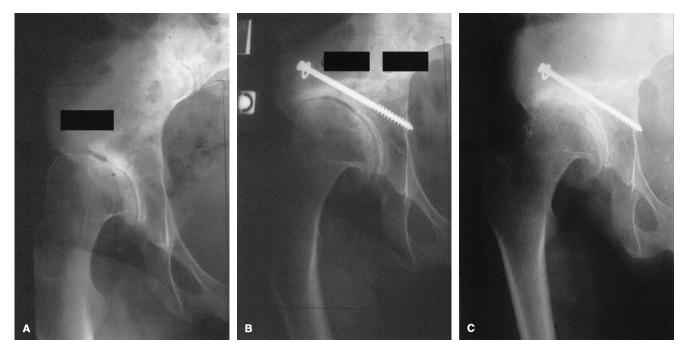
A, Preoperative AP radiograph shows a 35-year-old woman with a late evolution of congenital hip dislocation surgically reduced during childhood. Hip arthrosis was severe (Grade 4) with a joint space narrowing. The dysplasia also was severe, with a center edge angle of -10° . The patient had a severe subluxation and a deformity of the femoral head. B, Nine years after Chiari pelvic osteotomy, there was complete coverage of the femoral head and improvement of arthrosis. The functional hip rating increased from 11 points preoperative to 18 points at the last followup. C, Eighteen years after Chiari pelvic osteotomy, just before the conversion to a THR, there was an increase of arthrosis and the functional rating decreased to 14 points.
